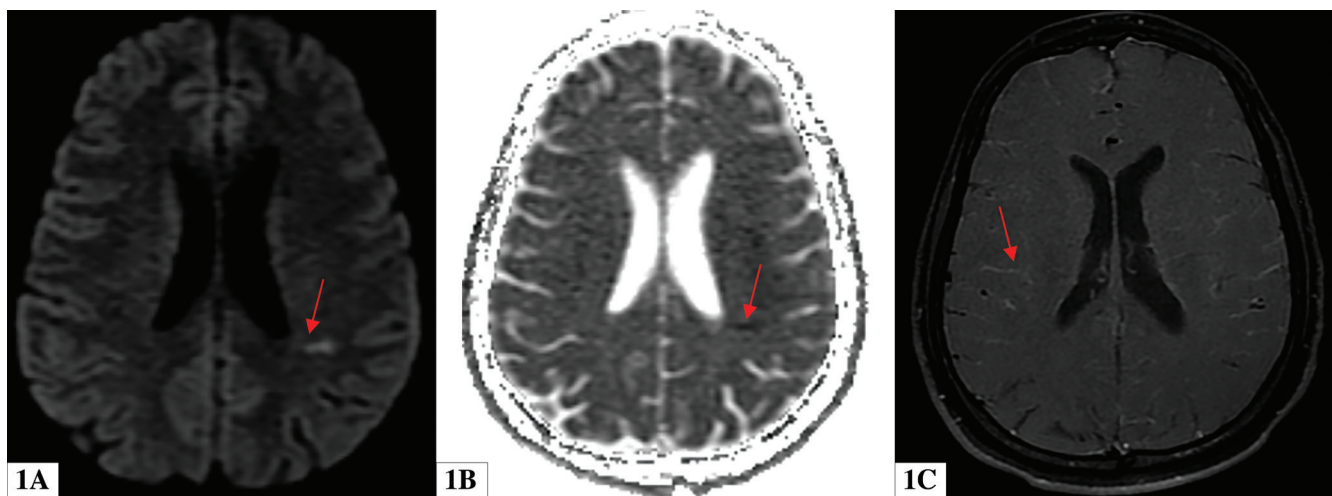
(1A) Brain MRI—axial diffusion-weighted imaging shows a hyperintense signal in the left parietal cortex, consistent with an acute infarct (red arrow). (1B) Brain MRI—corresponding apparent diffusion coefficient map shows a hypointense signal, confirming restricted diffusion (red arrow). (1C) Brain MRI—axial T1-weighted post-contrast image reveals diffuse leptomeningeal enhancement, typical of infectious meningitis (red arrow)
